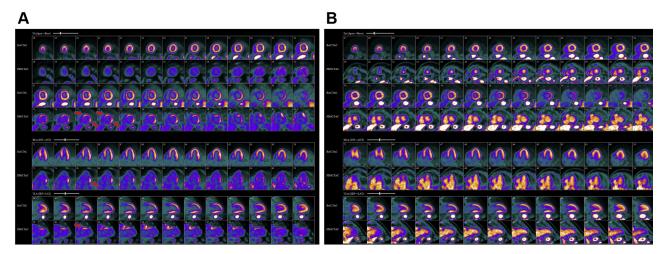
(A) Positron emission tomography (PET) scan with rest and (18)F-fluorodeoxyglucose positron emission tomography (FDG) uptake. PET scan showed illumination of FDG in the basal anteroseptal segment, basal inferolateral segment, basal anterolateral segment, and basal anterior segment indicating inflammation. The area of interest is marked with red arrows. (B) PET scan with FDG uptake: No discernable FDG uptake can be seen in these images.
